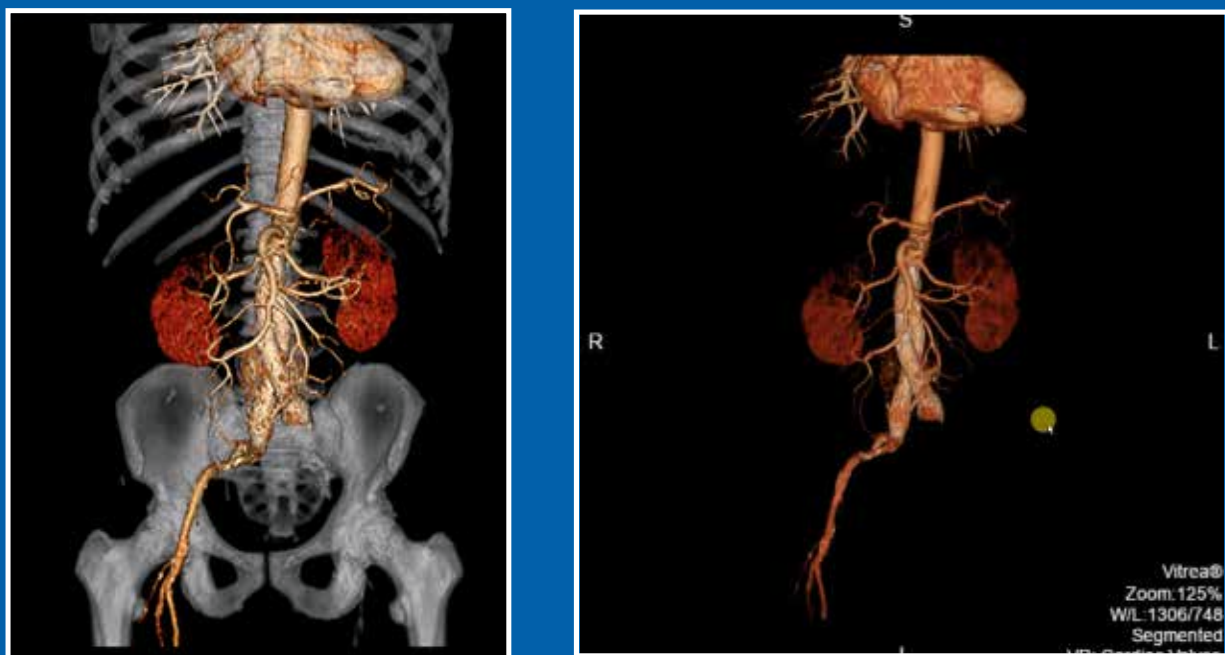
Multidetector CTA of Thoracic and Abdominal Aorta (video)
